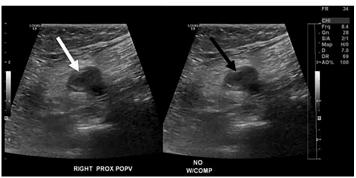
Ultrasound image from the patient's previous admission showing the popliteal vein on the right side without compression (white arrow) and with compression (black arrow). The popliteal vein at the time of this presentation was uncompressible, consistent with a venous thrombosis.
